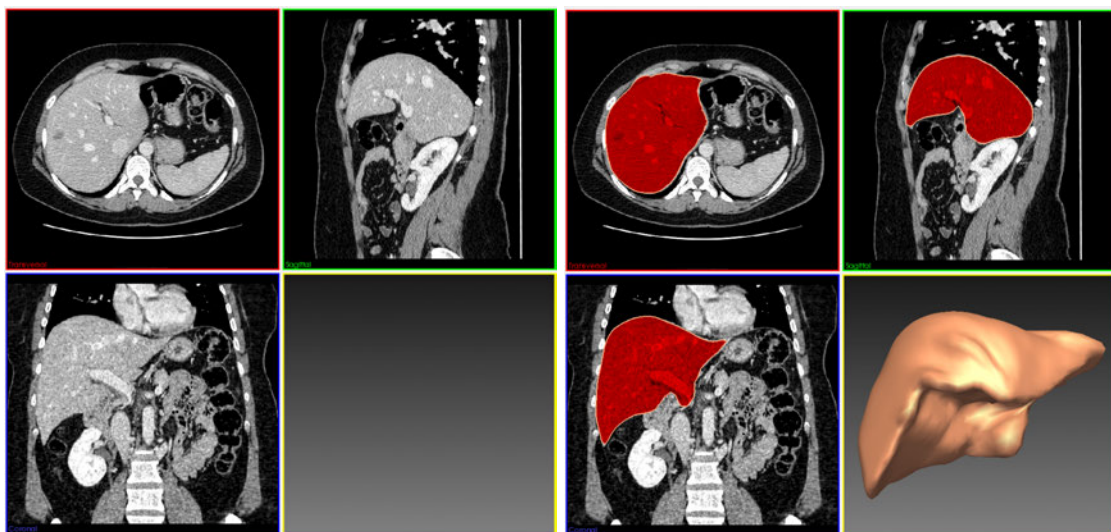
Left: 2D views of a CT dataset. Right: Fully automatic organ segmentation.
